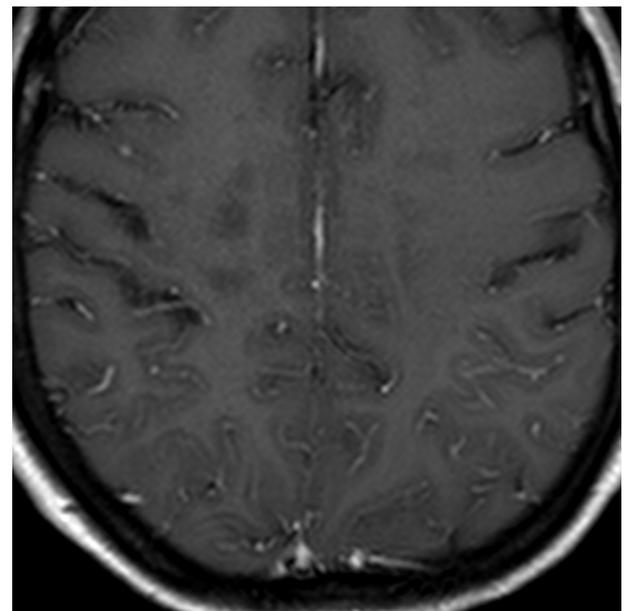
Axial T1-weighted post-contrast image on a follow-up brain MRI demonstrates diffuse leptomeningeal enhancement, most prominently in the bilateral parietal lobes.
